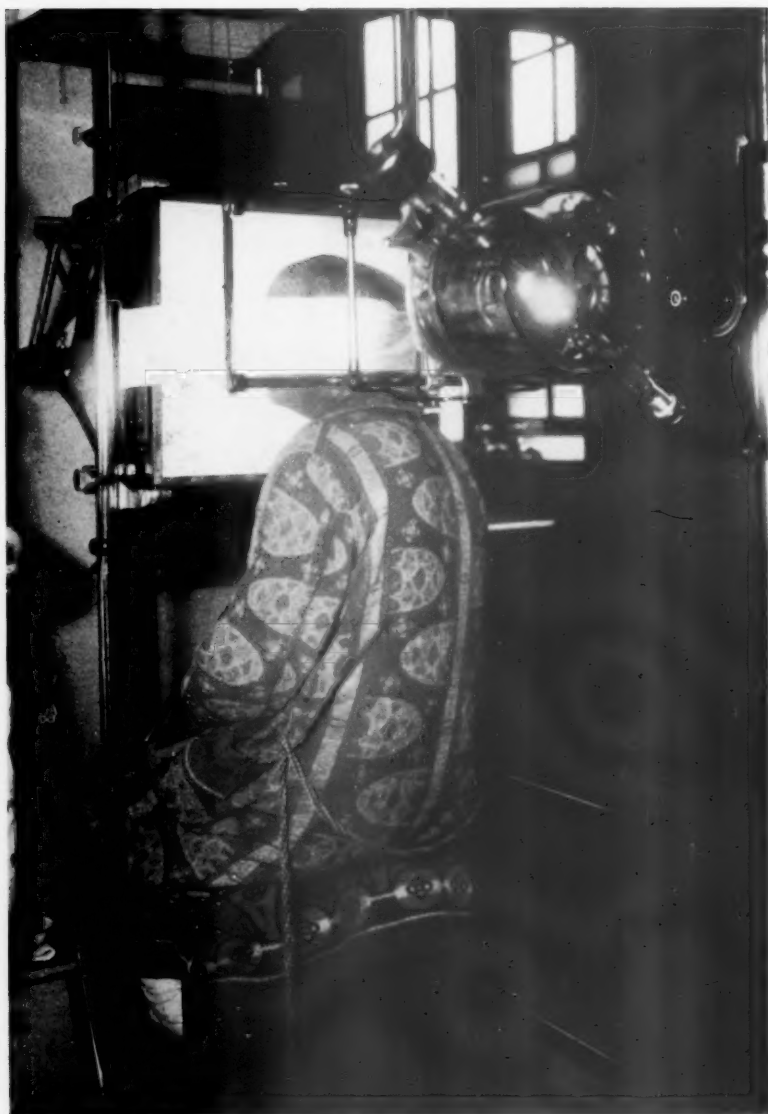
Showing roentgenological technique and apparatus used.
